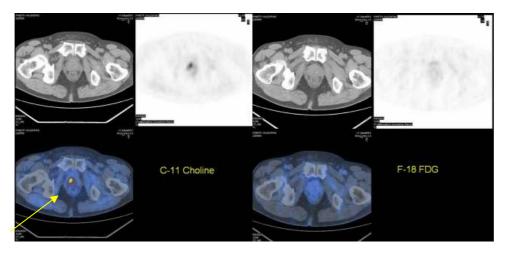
Prostate cancer: relapse after radiation therapy treatment; PET scan using C-11 choline detects a recurrence that went undetected both after CT scan and FDG PET (arrow).
